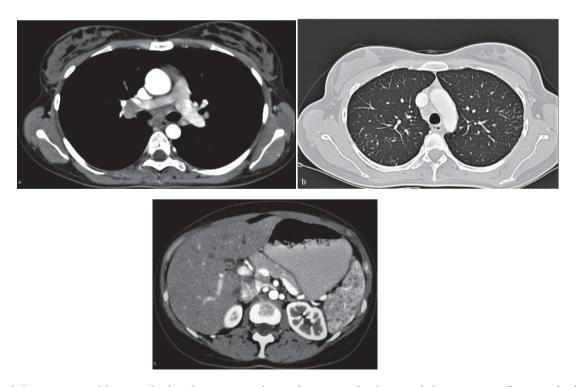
A: Axial chest CT image (chest window) with IV contrast (arrows), B: Coronal reformatted chest CT image (lung window), C: Axial abdominal CT image with IV contrast.
